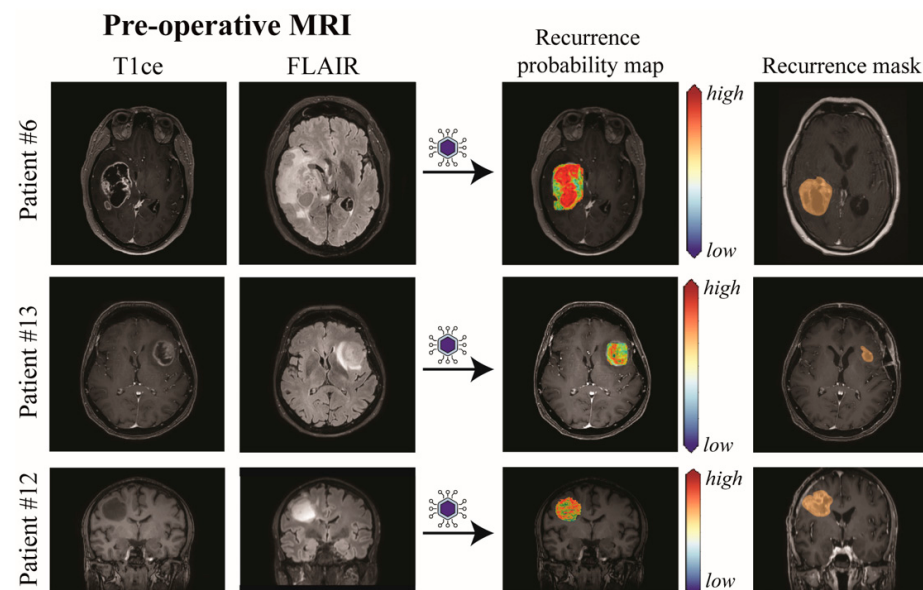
Representative challenging cases from the independent test set. For each patient, the figure shows the preoperative MRI, the predicted recurrence-risk map, and the corresponding recurrence region identified on follow-up MRI after co-registration.
